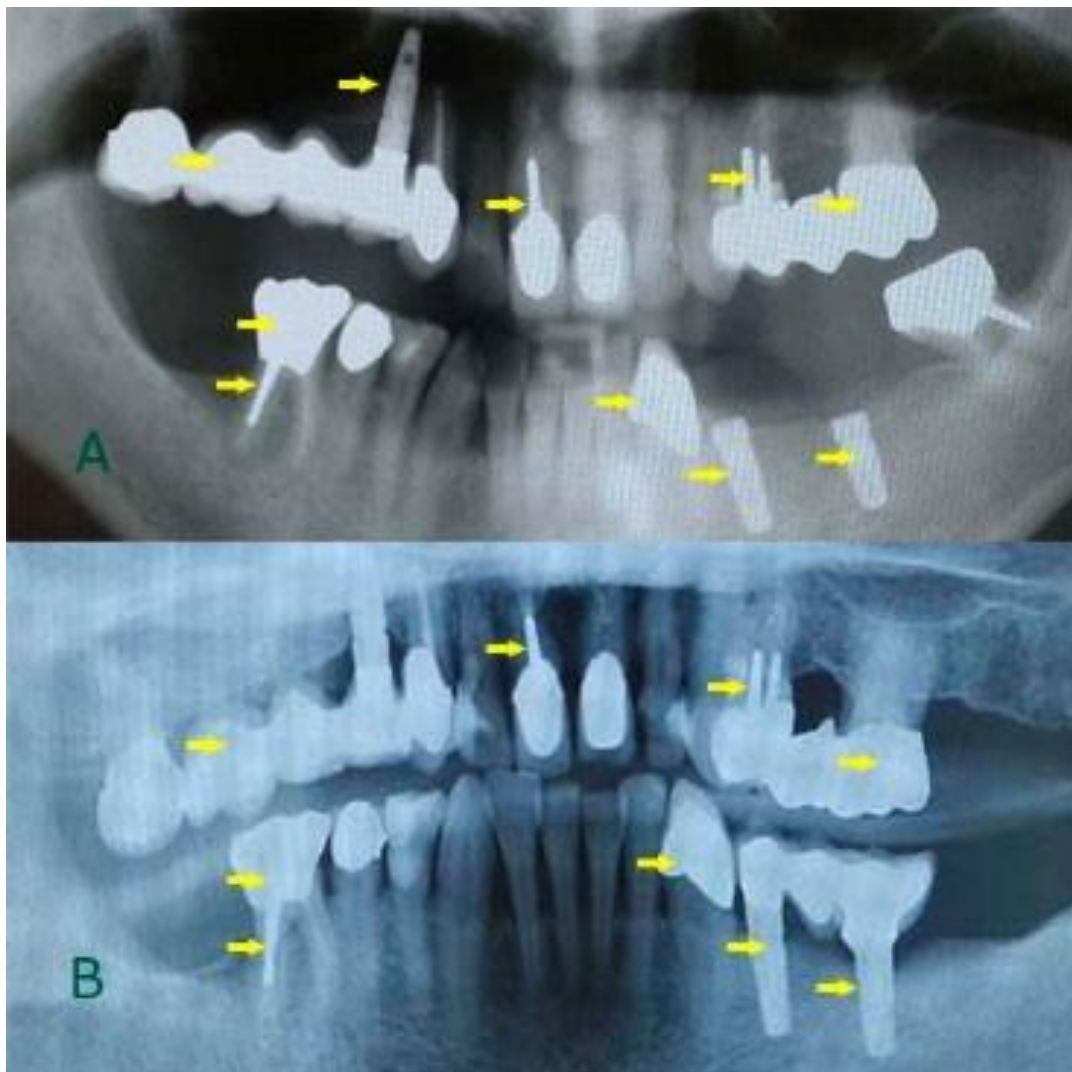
(A) *antemortem*; (B) *postmortem*. Yellow shafts show positive comparisons between panoramic x-rays.
